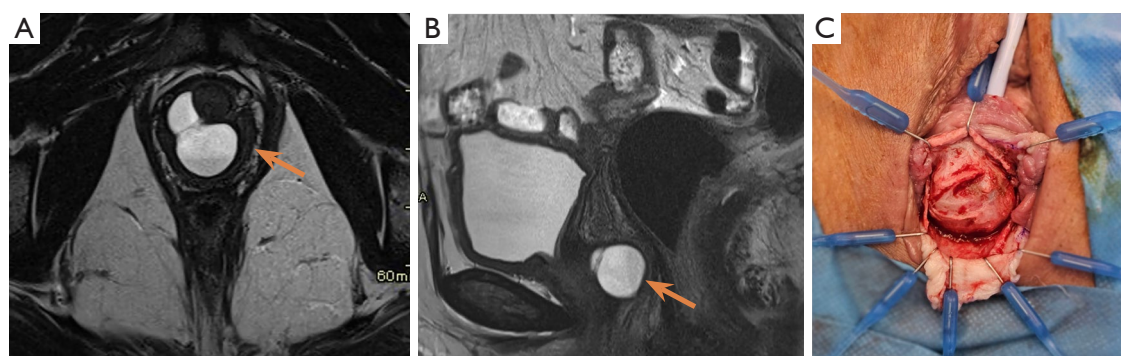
Pelvic MRI with VSD showing a saddle-shaped urethral diverticulum (orange arrows) in the right posterolateral aspect of the mid-urethra. The lesion appears hyperintense on T2-weighted images (A,B) and hypointense on fat-saturated T1 images. Post-contrast VSD images show peripheral enhancement. No signs of complication are seen. Intraoperative images show the diverticulum exposed through an inverted U-shaped anterior vaginal wall incision and horizontal dissection of the periurethral fascia (C). MRI, magnetic resonance imaging; VSD, vaginal saline distension.
